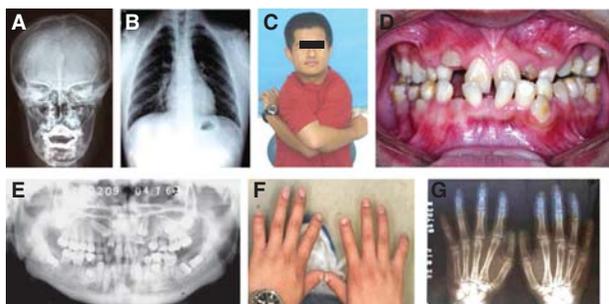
Typical clinical manifestations of CCD: (A) Radiograph showing non-closure of the fontanels, with clearly visible sutural bones. (B) Chest radiograph showing consecutive interruptions in the distal right clavicle, left clavicular aplasia. (C) Hypermobility of both shoulders due to clavicular aplasia. (D) Photograph showing deciduous and supernumerary teeth. (E) Dental panoramic radiograph showing deciduous, supernumerary and impacted teeth. (F and G) Distal phalanx dysplasia.
